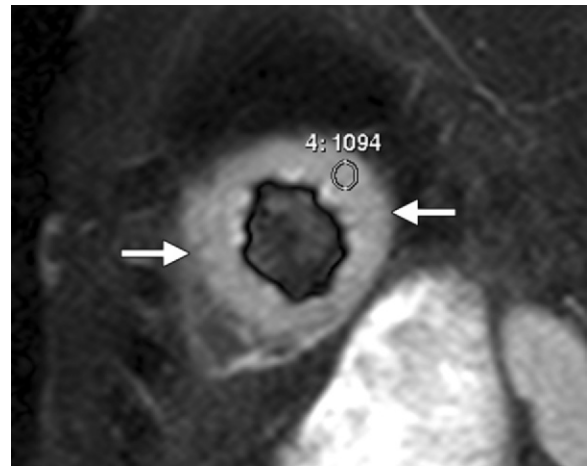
Short-axis T2-weighted STIR image in a 67-year-old woman with acute chest pain and ST-segment elevation shows diffuse myocardial edema (arrows). There was no delayed hyperenhancement (not shown).
